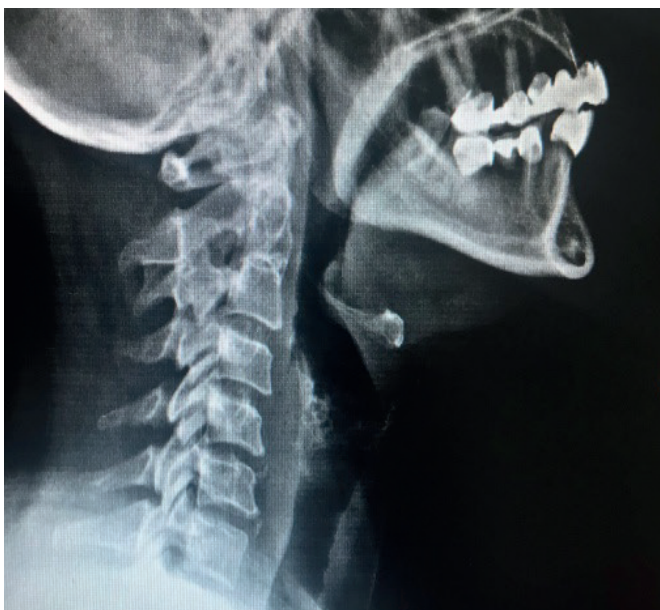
Radiograph of the servical spine.
